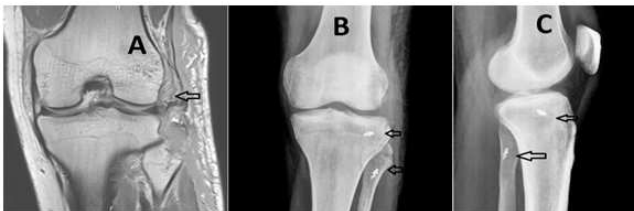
Traumatic avulsion of the lateral collateral ligament and capsule (A) of the knee as indicated by the arrow. The anteroposterior (B) and the lateral radiograph (C) of the knee showing the repair of the collateral ligament and reattachment of the cap.
